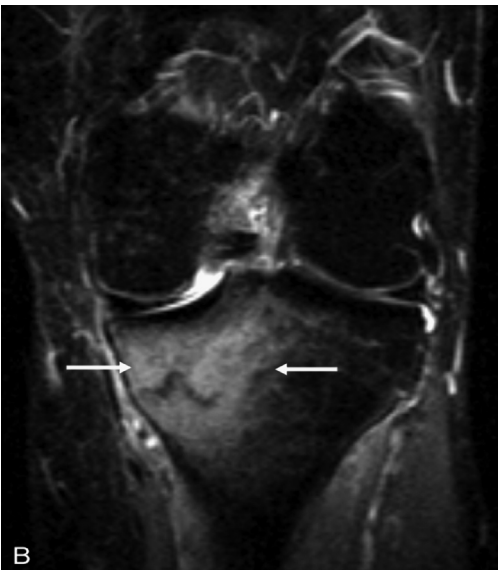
Stress fracture. (A) Coronal proton density-weighted turbo spin echo image. Running athlete with recurrent pain on the medial side of the knee. A stress fracture is demonstrated in the medial tibial metaphysis (arrow), which was not visible on plain radiography. (B) Coronal short tau inversion recovery image. There is extensive bone marrow edema surrounding the stress fracture (arrows).
